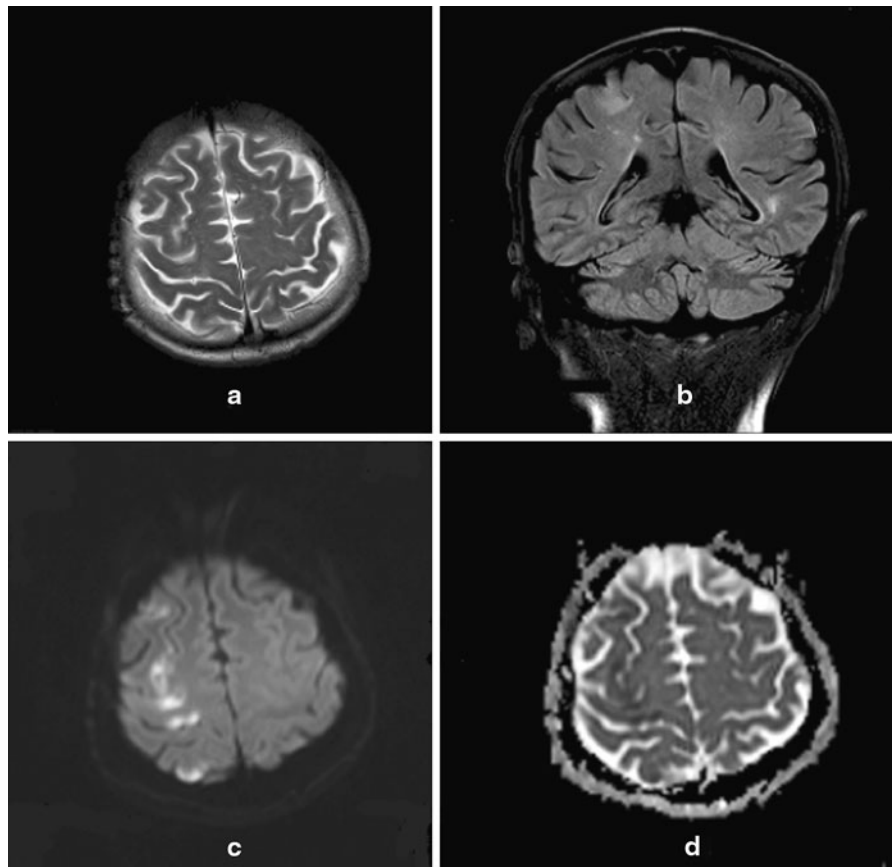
T2-weighted a MRI and FLAIR sequence b show cortical hyperintense areas at the initial stage. Corresponding diffusion-weighted MRI (c b1000 image and d ADC map) reveals restricted diffusion consistent with acute cortical watershed infarction
